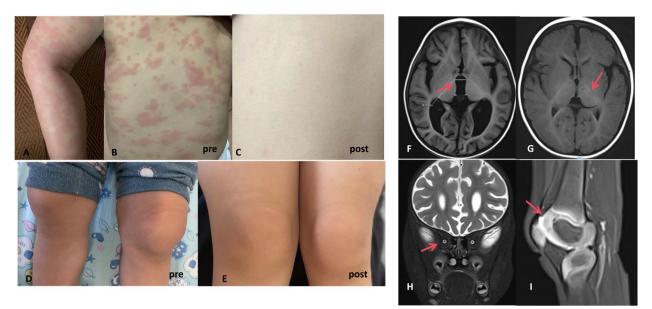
Phenotype of CAPS patients. A, B urticaria-like rash before canakinumab treatment; C rash after canakinumab treatment. D swelling of bilateral knee joint before canakinumab treatment; E knee joint swelling relieved after canakinumab treatment. F, G (before canakinumab treatment): ventriculomegaly and abnormalities in thalamus in brain magnetic resonance imaging; H optic neuritis in eye magnetic resonance imaging; I synovial enhancement and fluid in keen joint in magnetic resonance imaging
